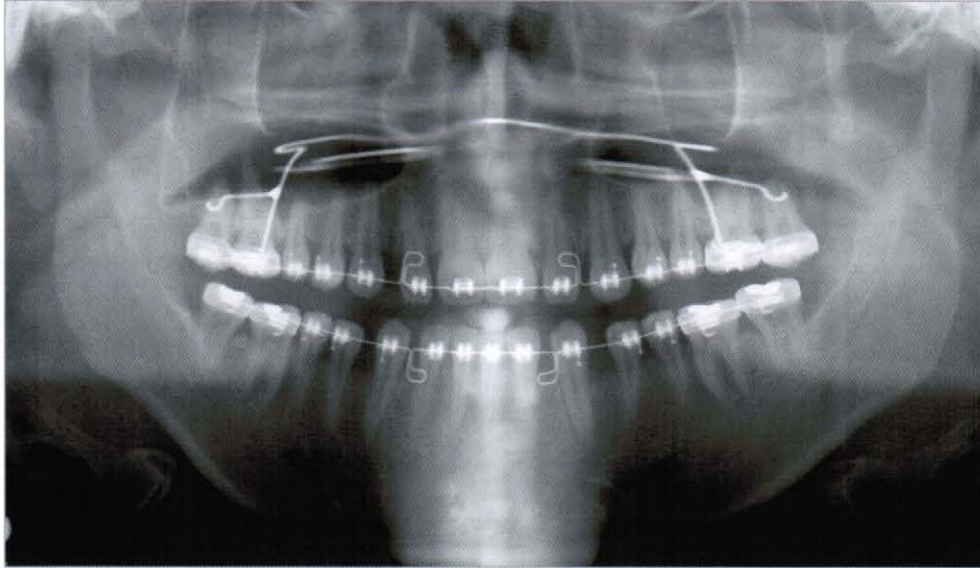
Panoramic radiograph after leveling
